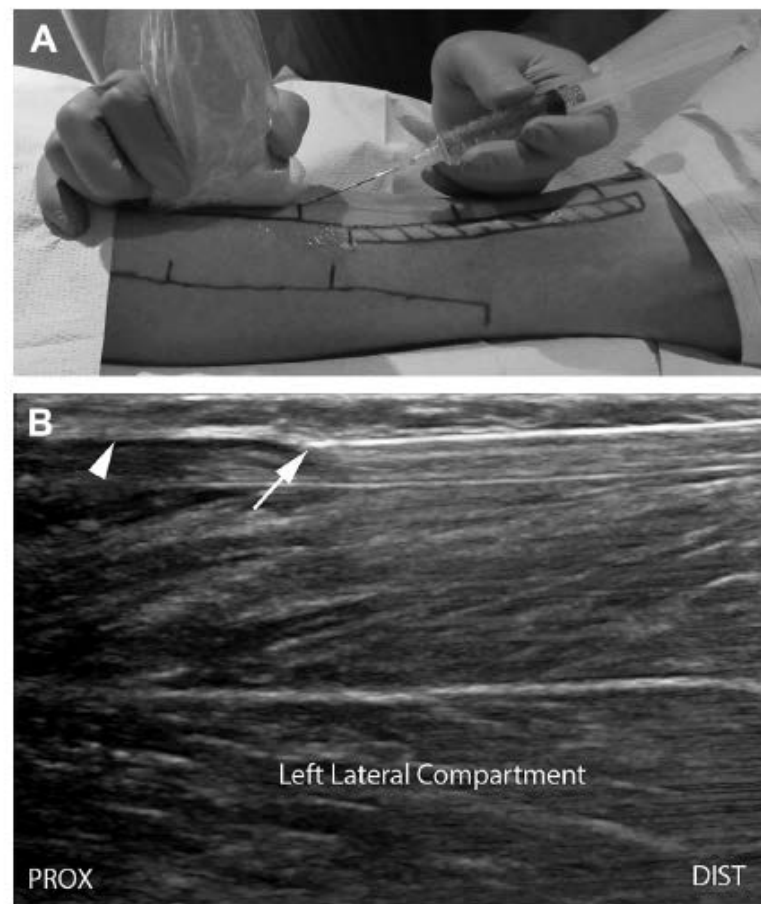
(A) An 18-gauge needle entering the skin under sonographic guidance to fenestrate a segment of the lower leg anterior compartment. Proximal = left side of the figure; distal = right side of the figure; anterior = top of picture; posterior = bottom of picture. (B) Long-axis ultrasound image of the needle fenestrating the left lateral compartment of the lower leg. Arrow = needle tip; arrowhead = fascia; PROX = proximal; DIST = distal.
